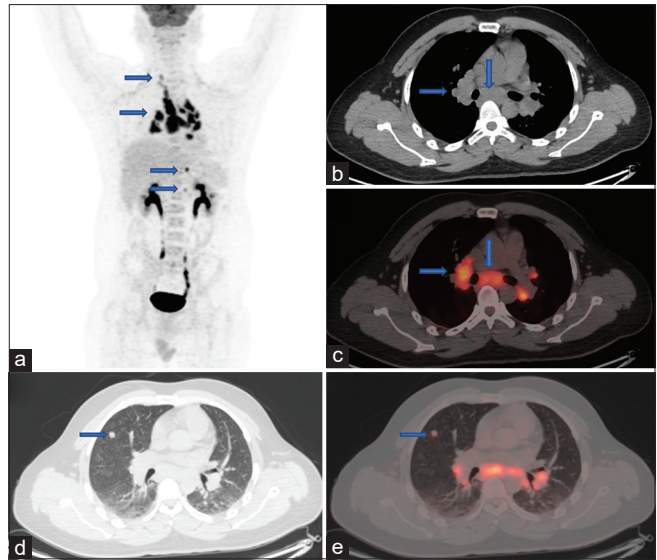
(a) Maximum intensity projection (MIP) image of a 29-year-old male with metabolically active lymph nodes (arrows) in the right supraclavicular, mediastinal, celiac, and left para-aortic locations. Axial CT image (b) of the same patient showing multiple enlarged mediastinal lymph nodes (arrows) with increased metabolic activity on axial fused PET-CT image (c). Axial CT image in lung window (d) showing a well-defined rounded nodule in right lung upper lobe (arrow) with increased metabolic activity on axial fused PET-CT image (e)
